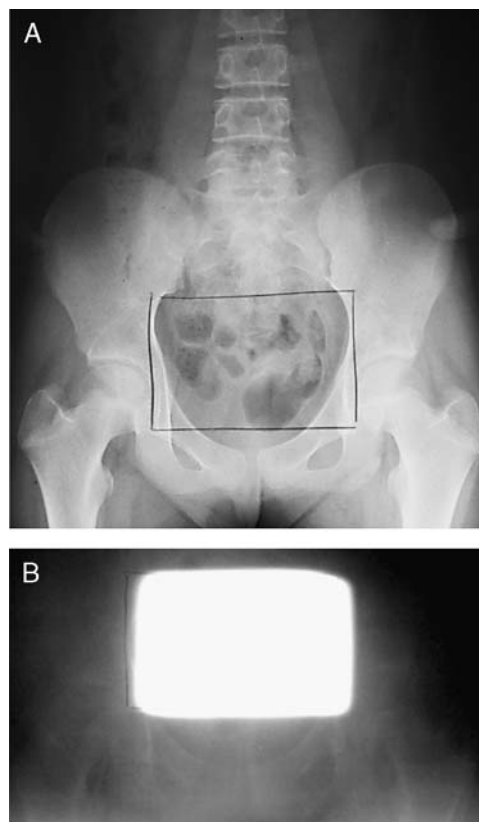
A, Radiograph for confirmation of the uterine and ovarian shielding location. The box shows the location of the lead block. B, A portal image obtained at the location of the uterine and ovarian shielding in TBI. TBI indicates total body irradiation.
